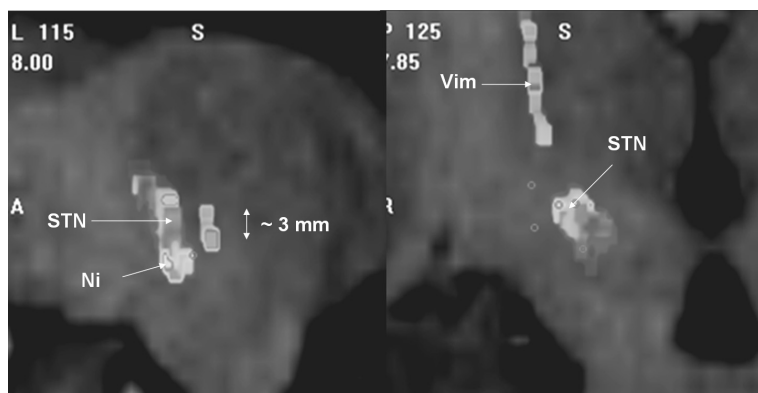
Mean Burst Index in our electrophysiological atlas color-coded and superimposed on the MR images (Left, a sagittal view; right a coronal view). Bright and dark pixels correspond to high and low values, respectively. Regions that correspond to various nuclei are shown with arrows.
